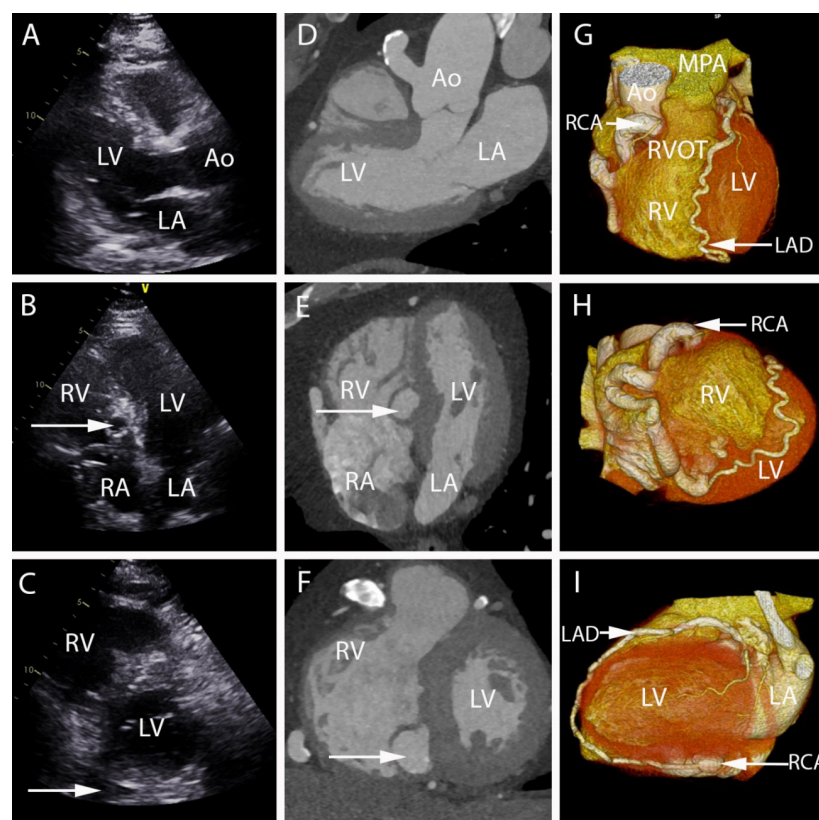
A-C) show the parasternal long axis (1A), apical 4-chamber (1B) and short axis (1C) TTE views of the left ventricle. The white arrow shows the presence of a spherical structure in the 4-chamber view and a dilated blood vessel in the short axis view. D-F) show the corresponding CTCA appearances of these findings in the same “echocardiographic views”. G) shows the 3D volume rendered image of the heart with dilated and tortuous RCA and LAD. H) shows the anatomical connection of the RCA fistula to the base of the inferior RV and a continuation of the PDA to the LAD and I) shows the LAD to PDA continuation. LV: left ventricle; RV: right ventricle; LA: left atrium; RA: right atrium; Ao: aorta; MPA: main pulmonary artery; RVOT: right ventricular outflow tract; TTE: transthoracic echocardiogram; CTCA: cardiac computed tomography angiography; RCA: right coronary artery; LAD: left anterior descending artery; PDA: posterior descending artery.
